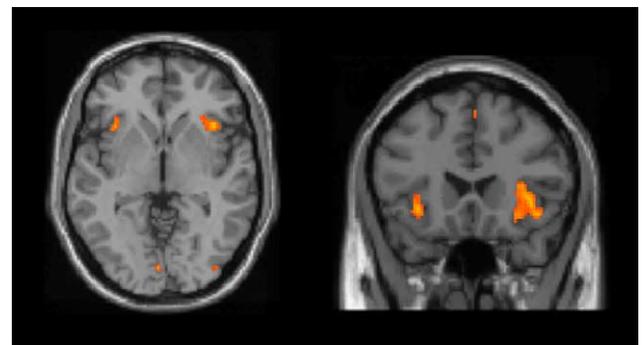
Bilateral activation of the anterior insula found when participants played the computer game to cooperate or to compete with another individual versus playing independently. Clusters are superimposed on a horizontal ($z = -8$) and coronal ($y = 24$) MRI sections.
